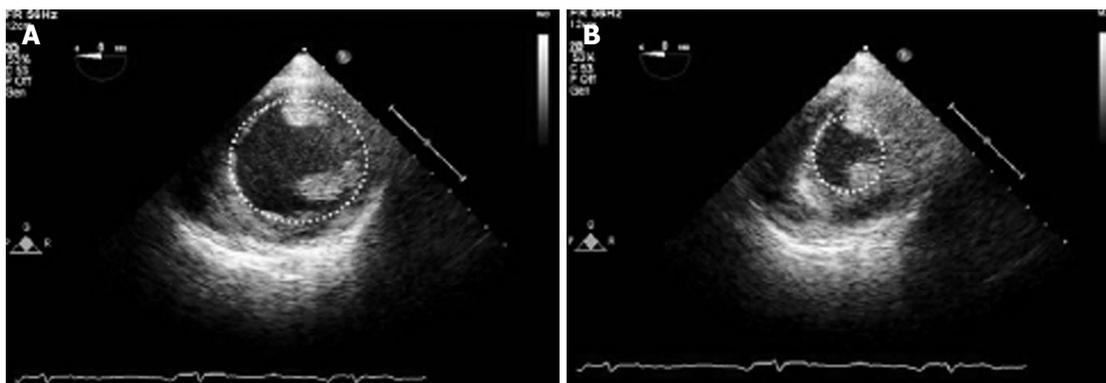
Transoesophageal measurements of fractional area change. Transgastric Mid SAX view of the left ventricle showing measurement of left ventricular end diastolic area (A) and left ventricular end-systolic area (B). The bidimensional image is usually best imaged at a multiplane angle of 0°. Modified by Guarracino Fabio *et al*^[61].
